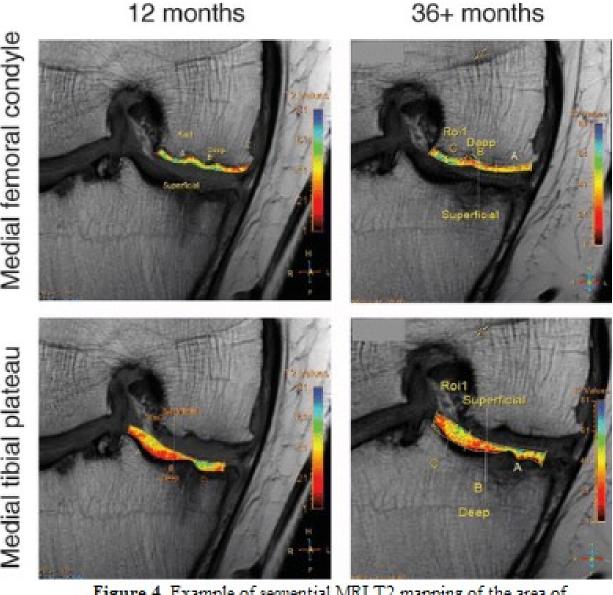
Example of sequential MRI T2 mapping of the area of cartilage regeneration at 12 and 36+ months. (Freiteg, 2020)
